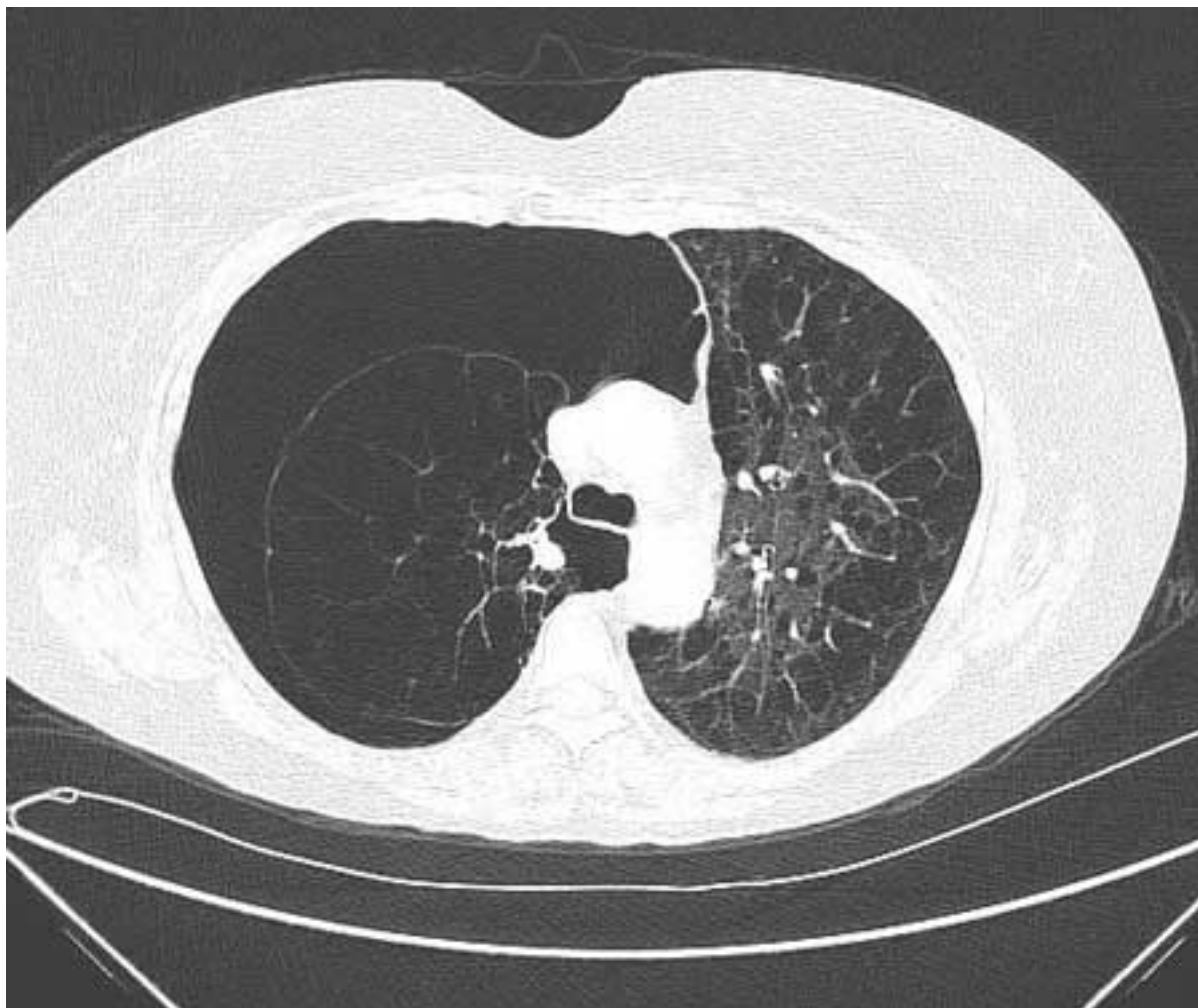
Chest CT: severe COPD changes with right pneumothorax
